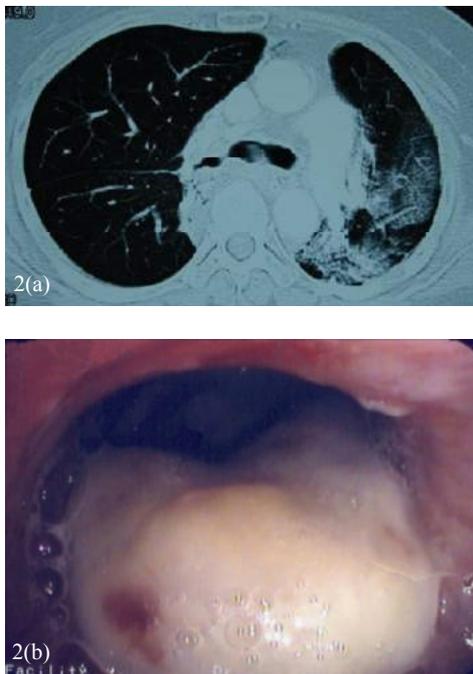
(a) CT scan showing recurrence of subcarina tumour with invasion and near total occlusion of the right main bronchus, (b) regrowth of the tumour 2 weeks after diathermy resection to obstruct about 60% of the right main bronchus lumen.
